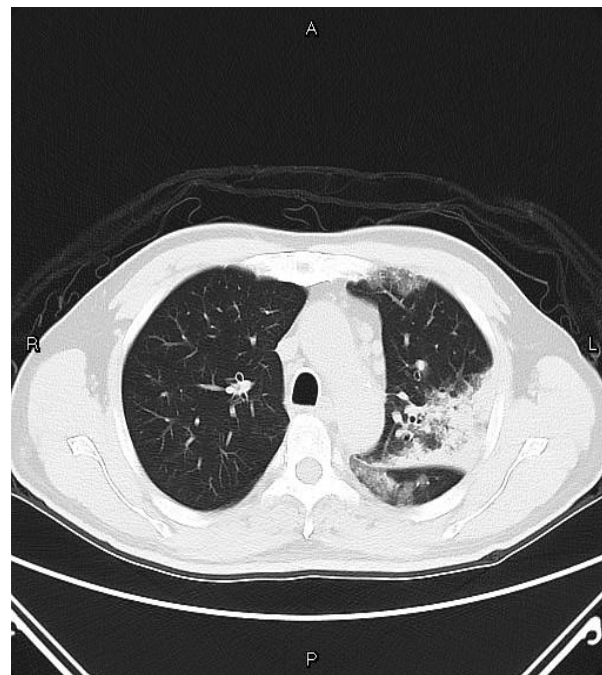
Consolidative change of left lung parenchyma on computed tomography of chest in a 58-year-old patient with non-productive cough for ten months, and shortness of breath with wheeze in the past one month.
